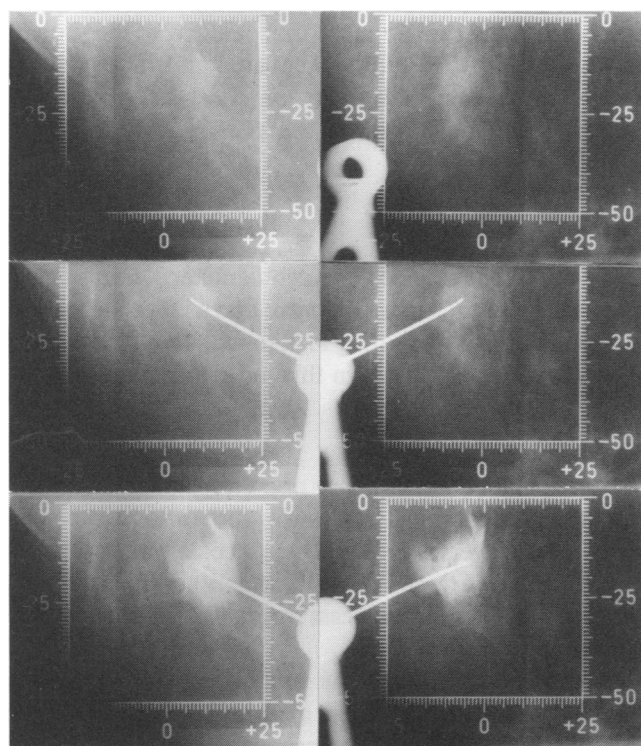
The different steps involved in localization and sampling. *Top*. The breast is positioned so that the suspected lesion is seen within the compression plate window. *Middle*. Control radiograph to confirm the position of the needle tip before sampling is commenced. *Bottom*. Appearance of the lesion after its localization with methylene blue and prior to open biopsy.
